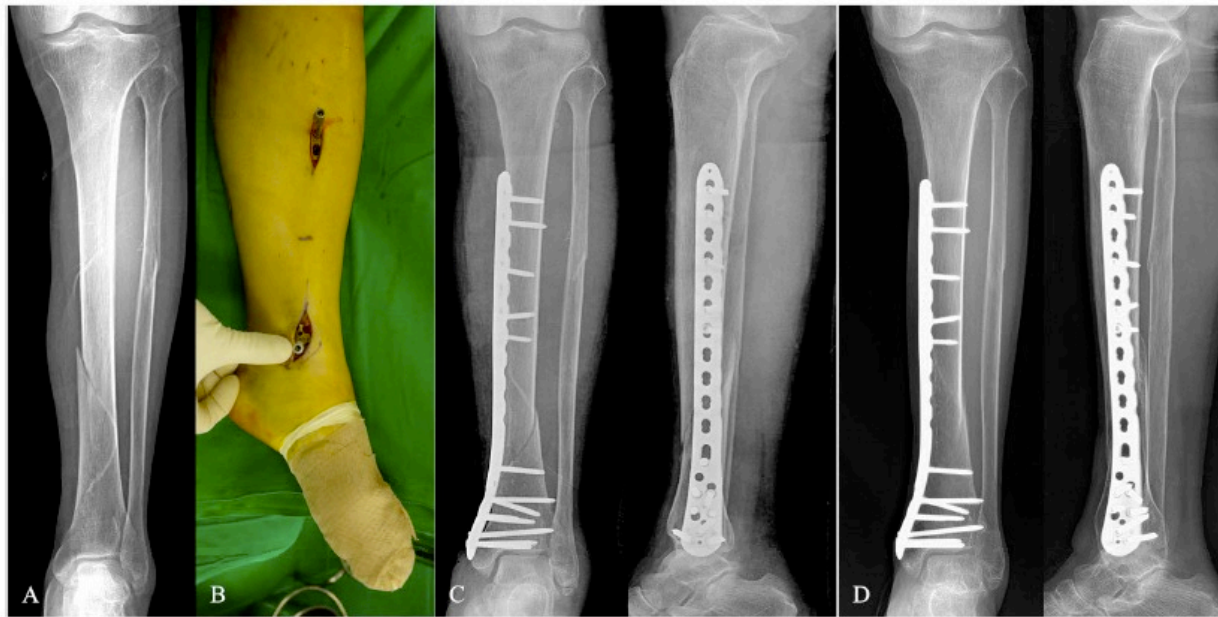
A, An 82-year-old woman who sustained a distal tibial shaft fracture (OTA/AO type 42 A1). B, The fracture was treated using minimally invasive plate osteosynthesis. C, Postoperative radiographs show acceptable alignment. D, The fracture healed with callus formation 16 weeks postsurgery.
